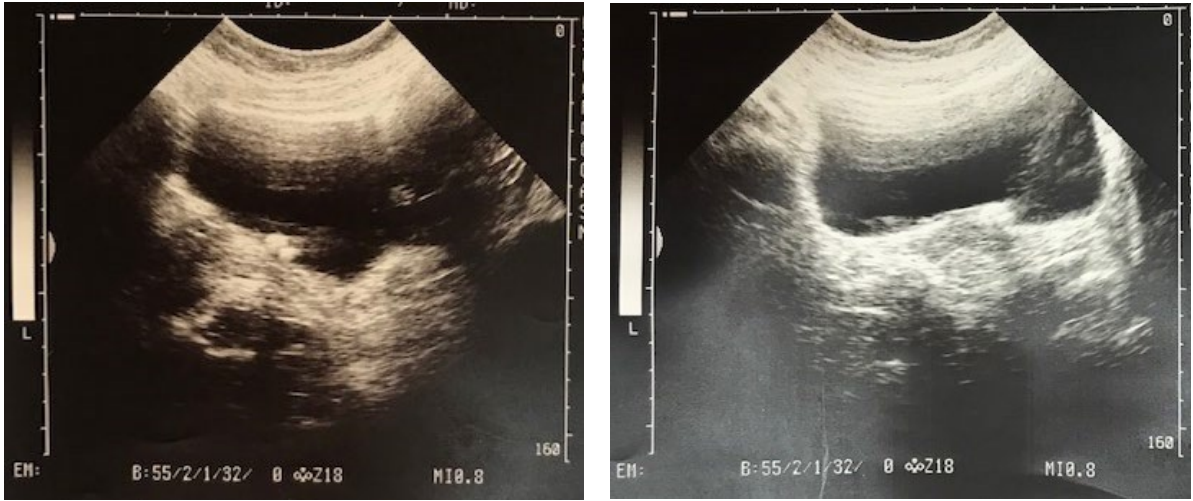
Bladder ultrasound with stone in the right intramural ureter. In the sagittal cut, two hyperechogenic images are seen on the posterior face of the bladder near the mouth of the ureter.
